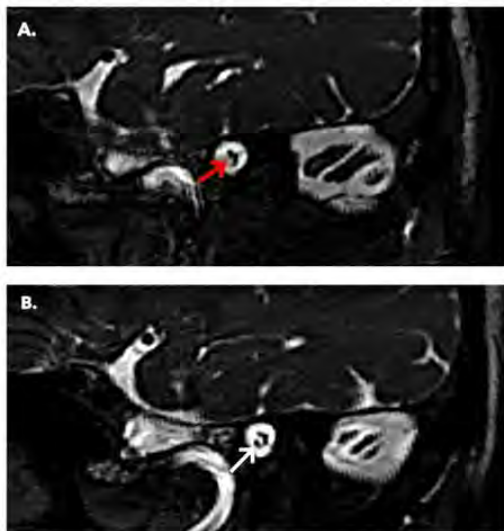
Oblique planes of sagittal high resolution T2-weighted images at left (A) & right (B) internal auditory canals that show a presence of cochlear nerve in the left side (white arrow), and absent cochlear nerve in the right side (red arrow).
